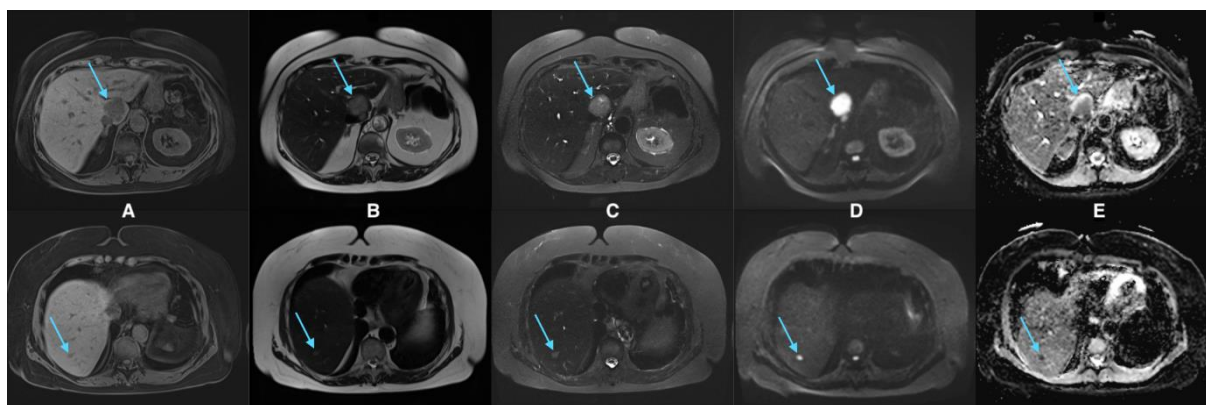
AMRI protocol presenting liver metastasis (blue arrow) characteristics seen in T1 (A), T2 (B), T2 STIR (C), DWI b800 (D) and ADC (E) sequences.
